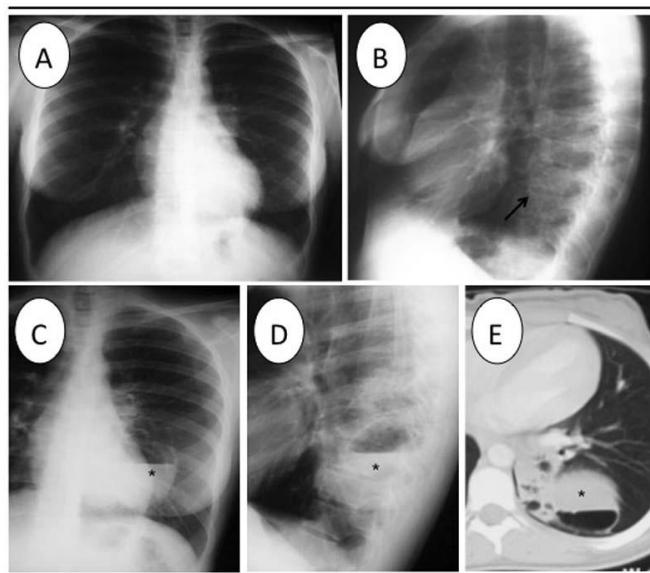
24 year old male with probable pulmonary sepsis. In a previous study (3A and 3B), a multicystic lesion on posterior left segments was observed(asterisk). This was not easy to recognise on the PA projection, when the patient was asymptomatic. Superinfection of these densities as seen from the air-fluid level (asterisk) indicated a cystic adenomatoid malformation (MAQ) or sequestration as predisposing factor to infection in the CRX (3C and 3D) and CT with lung parenchyma window(3E). The existence of the MAQ was confirmed during surgery.
